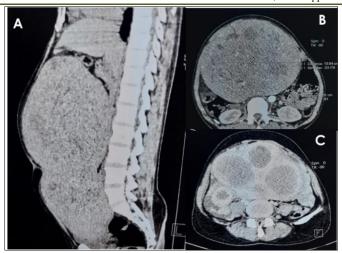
Abdominal CT in parenchymal window
